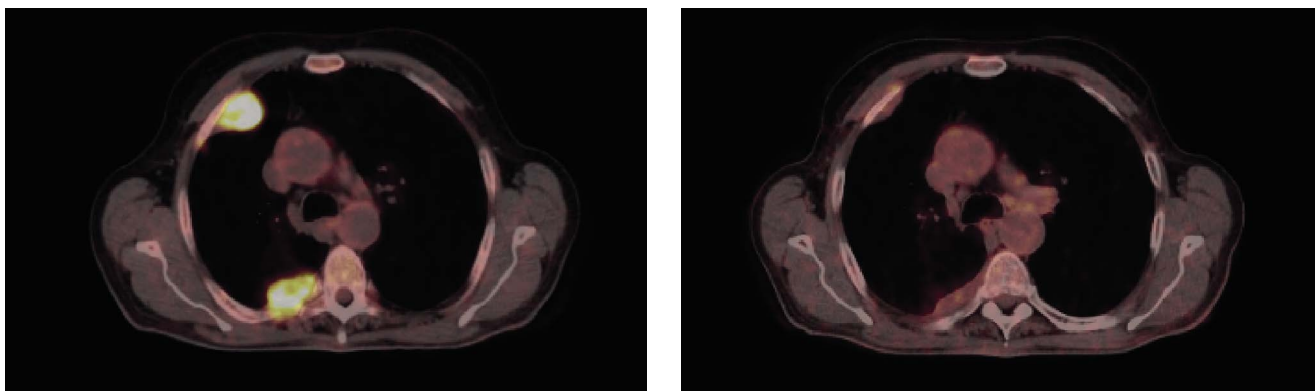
FDG-PET-image of a patient included in this study. Left: PET at baseline. Right: PET 6 weeks after start of treatment with ipi/nivo and UV1-vaccine. The images show conventional single-time scan at 60 minutes
